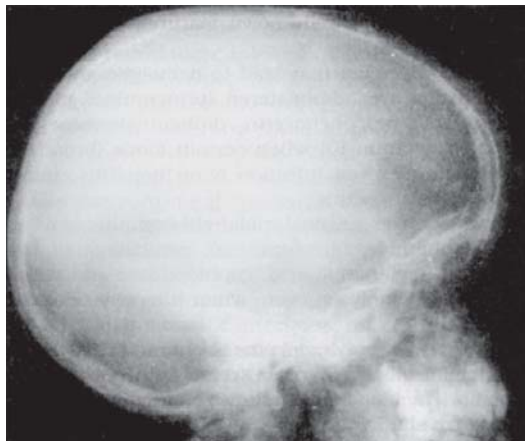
X-ray of skull showing hair-on-end appearance (caused by vertical trabeculae) in thalassemia major. Also note that the diploic spaces are significantly widened. Such a roentgenographic picture may occasionally be seen in chronic iron-deficiency anemia (IDA).
